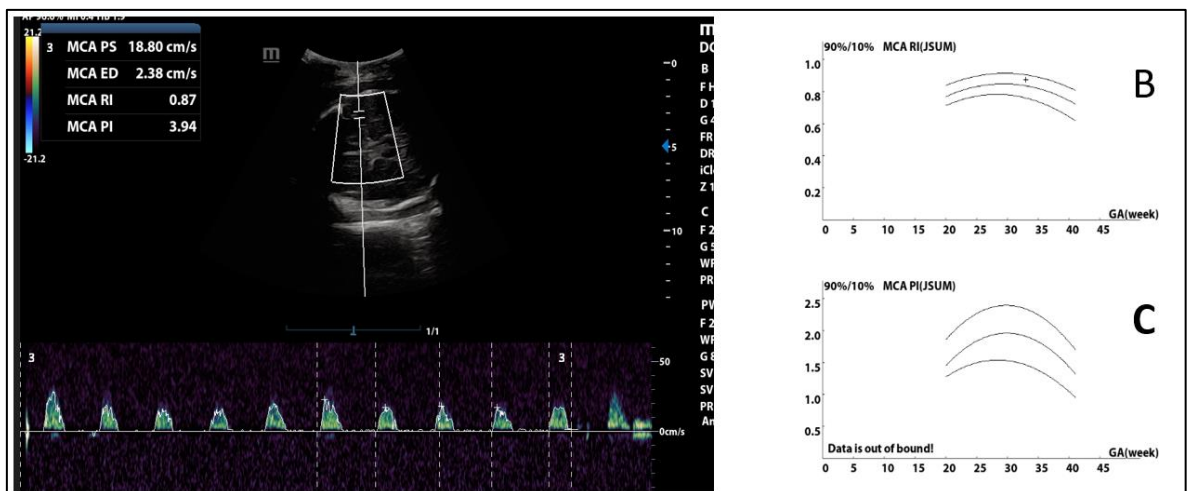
Middle cerebral artery color and spectral Doppler [A], showing absent diastolic flow, B), normal resistance index [RI-0.87] within 90<sup>th</sup> to 10<sup>th</sup> percentile and C), Very high pulsatility index [PI-3.94] above 90<sup>th</sup> percentile per gestational age and beyond the limit of 2.5
